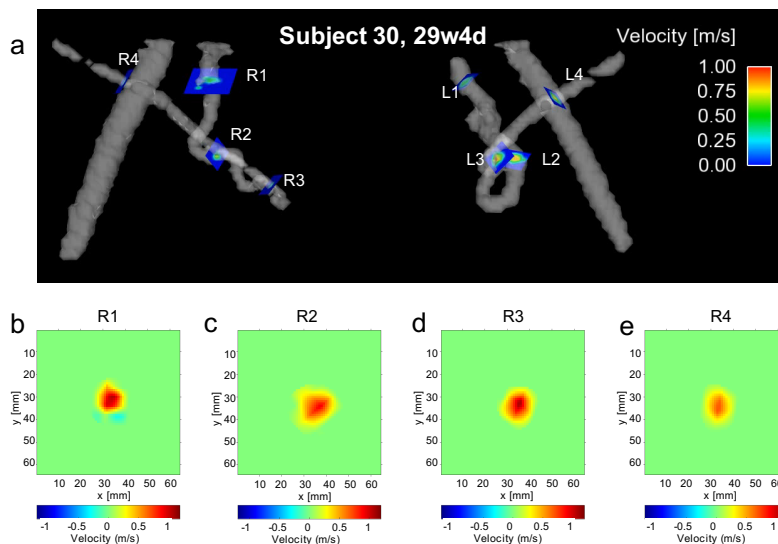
a) The eight 4D flow planes, four planes on each side, distributed along the UtAs in Subject 30. Planes R4 and L4 were estimated to correspond with the location of Doppler US velocity measurements. The interpolated velocity profiles of planes R1 (b), R2 (c), R3 (d), and R4 (e) are shown.
